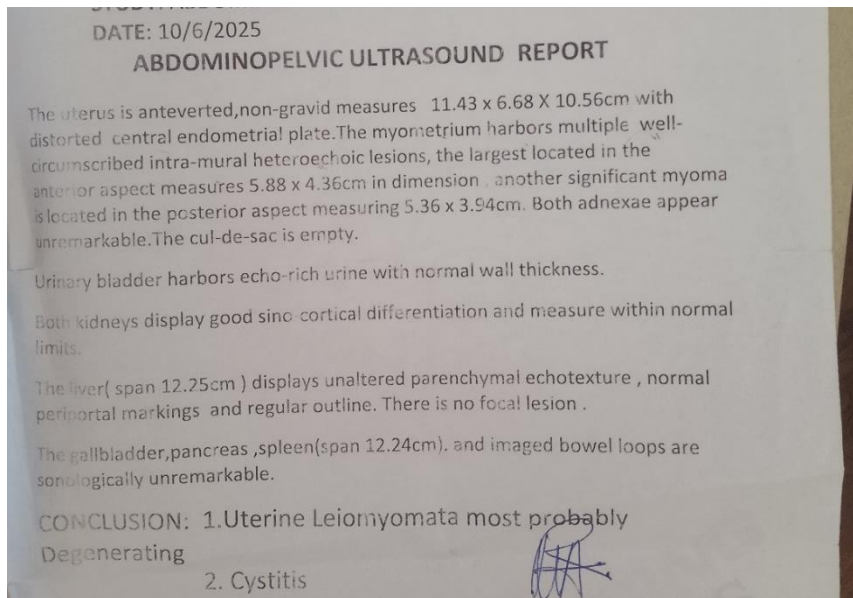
Abdominopelvic ultrasound
